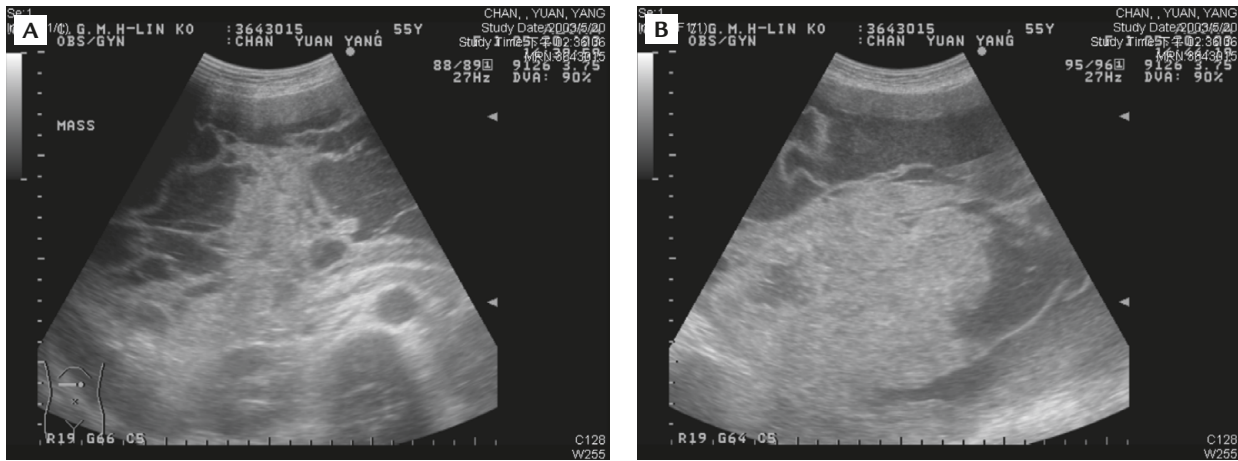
Transabdominal ultrasonography. (A) Several thick and irregular septa within the mass. (B) One soft tissue component covering the dependent part of the mass. No obvious ascites is present.
